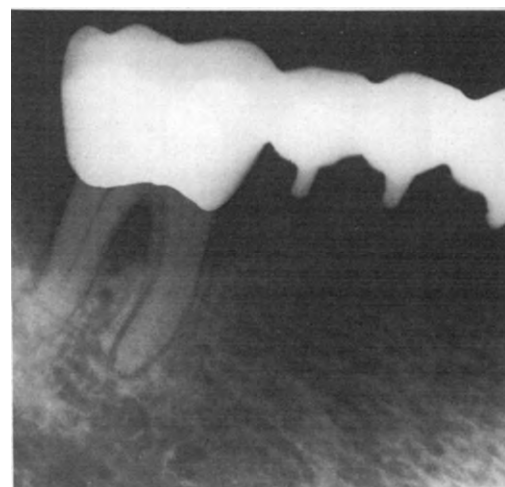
Top, radiograph of tooth shows significant periodontal disease of second molar with increased apical density. Patient reported pain and mobility. Bottom, photograph of extracted tooth and part of bridge. Note large extensive soft tissue mass attached to distal root lying in vertical plane, proved to be apical granuloma. As long as lesion is confined within cancellous bone and not encroaching on junctional trabeculae and masked by thick cortical bone, no radiographic visualization will occur.
